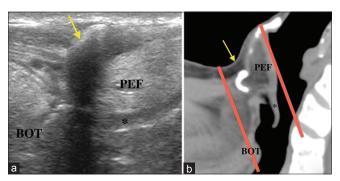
(a) Midsagittal section in the region of hyoid bone using linear transducer, demonstrating sonographic echogenic signature of the body of hyoid bone with posterior acoustic shadowing. (b) Corresponding computed tomographic section (red lines – representing limit of ultrasound scan extent) BOT: Base of tongue; PEF: Preepiglottic fat; asterisk, Epiglottis; Yellow arrow, body of hyoid bone
